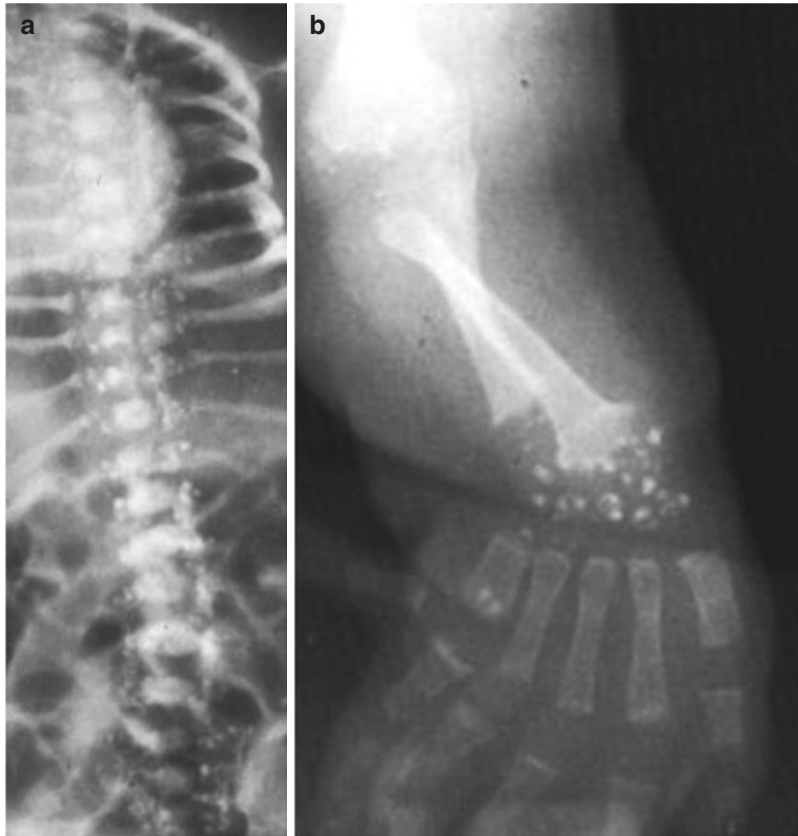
Chondrodysplasia punctata (Conradi-Hünemann subtype). (a) Frontal radiograph of the thoracolumbar spine shows punctate calcifications adjacent to
